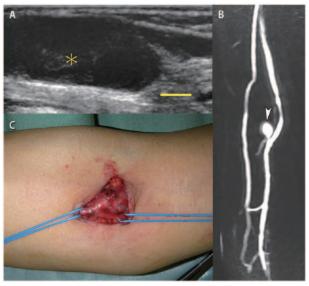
Duplex ultrasonogram, magnetic resonance imaging (MRI), and intraoperative findings of a soft mass (case 1). (A) Duplex ultrasonogram of the right basilic vein showing a venous pseudoaneurysm with intraluminal thrombosis (asterisk). Scale bar: 5 mm. (B) MRI shows a venous pseudoaneurysm in the basilic vein (arrowhead). (C) The aneurysm was resected after the identification and ligation of the feeding vessels of the basilic vein (blue vessel loops).
